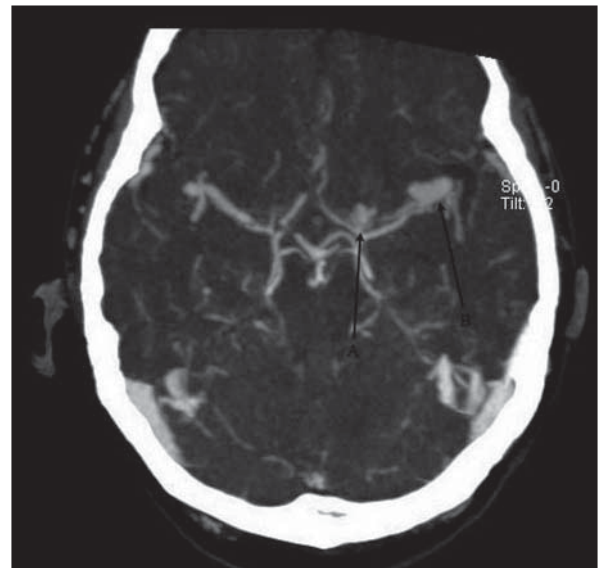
Left middle cerebral and left internal carotid artery aneurysm demonstrated on computed tomography angiography in the axial plane (arrowed).
